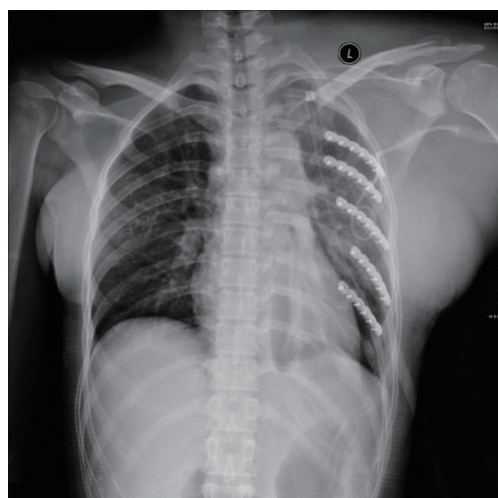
It showed the postoperative chest radiograph. The chest radiograph of the patient on the 8th day after surgery showed that the pleural effusion was basically drained clean.
